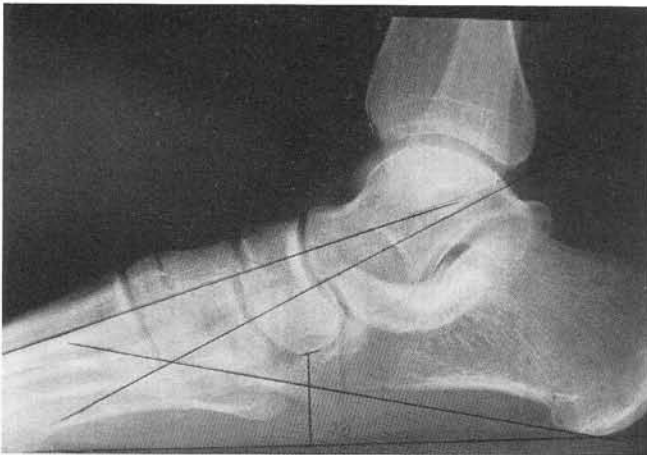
Lateral weight-bearing radiograph. Some early secondary changes are noted in the tarsal joints evidenced by increased sclerosis and some very early beaking at the medial column articulations. The deformity was considered semiflexible.
